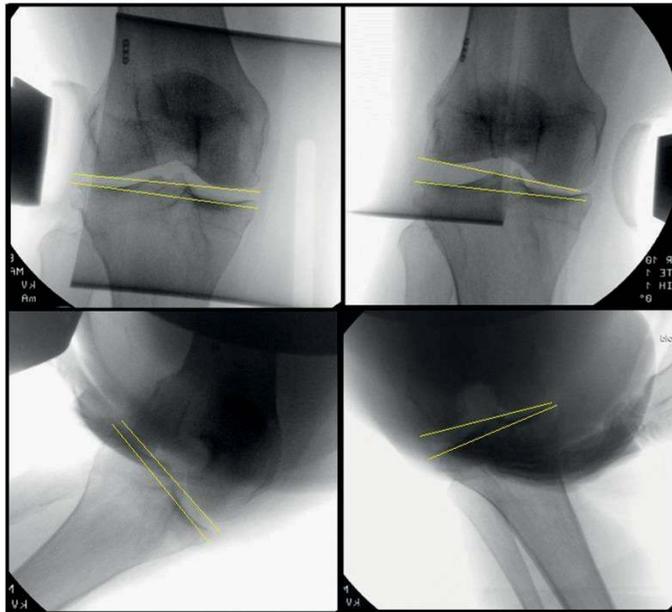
Valgus and varus laxity stress radiographs with joint space opening.
